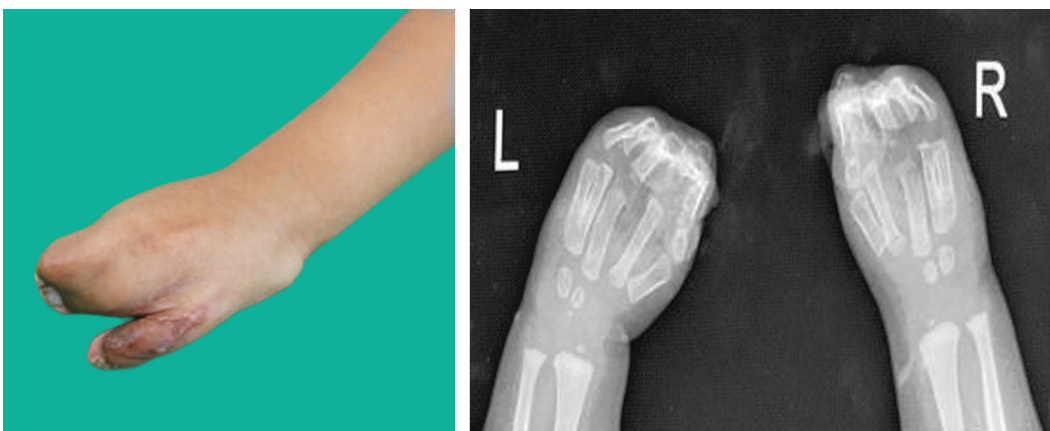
Clinical photograph of the defect and preoperative hand–wrist radiograph
